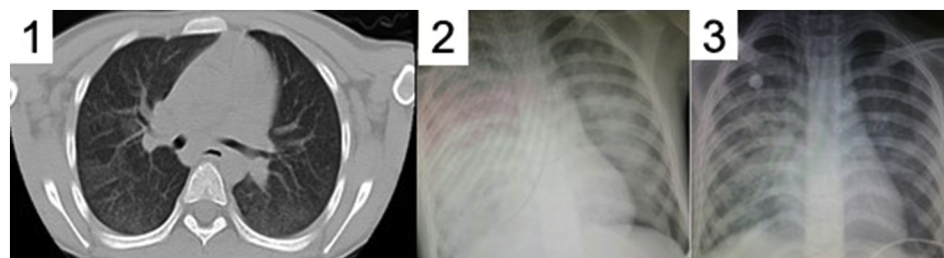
Series imaging of case 1. (A.1) Chest computed tomography shows bilateral ground-glass infiltrates in both lung fields on high resolution computed tomography; (A.2) chest radiography (postero-anterior view) on 1 day after admission revealing bilateral lobe consolidation with areas of profound confluence in the right lung during an acute phase of massive pulmonary hemorrhage; (A.3) chest radiography on 8 day showed marked clearing of infiltrates.
